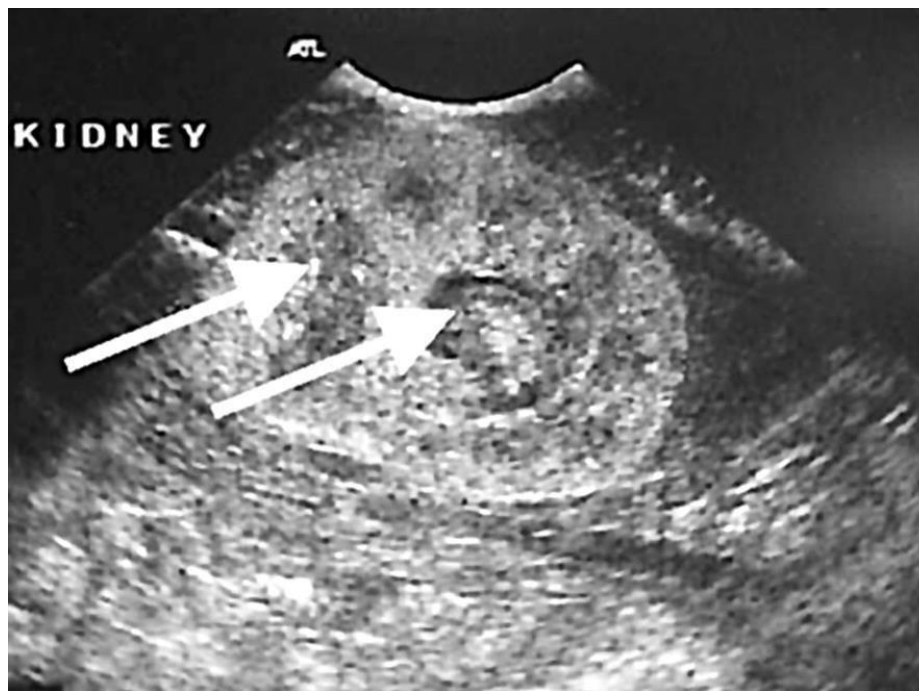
Fungus Ball appearance detected on renal ultrasound [8].
